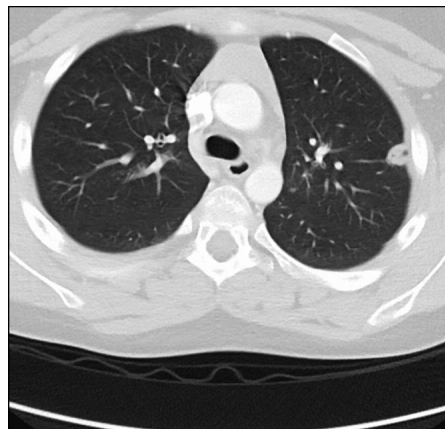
Chest computed tomographic image is showing pulmonary metastases.
